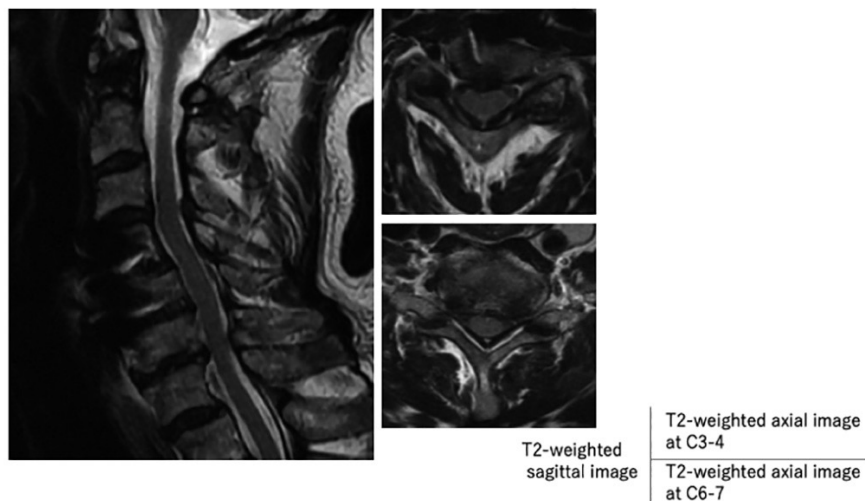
Follow-up MRI studies at 6 months after initial ACDF at C4-5. Although the initial operation at C4-5 improved C5 radiculopathy, a clinically silent, mild cord compression had developed at the adjacent C3-4 level.
